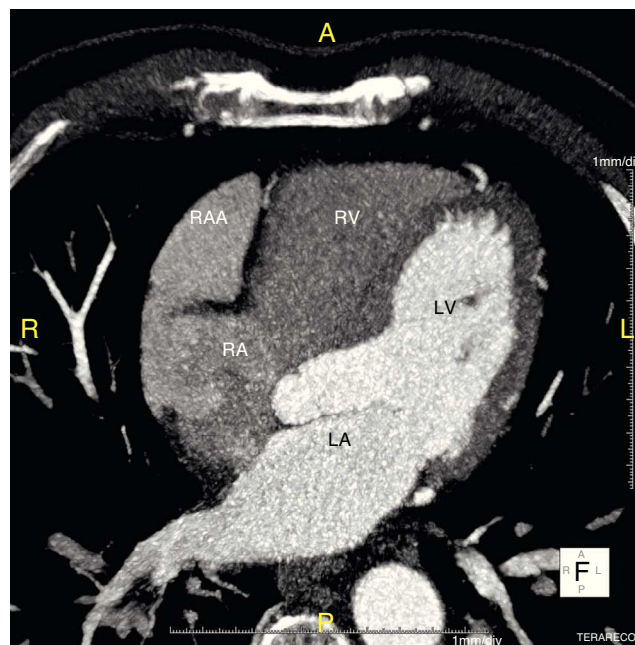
Computed tomography (CT) scan, axial view. LA: left atrium; LV: left ventricle; RA: right atrium; RAA: right atrial aneurysm; RV: right ventricle.
